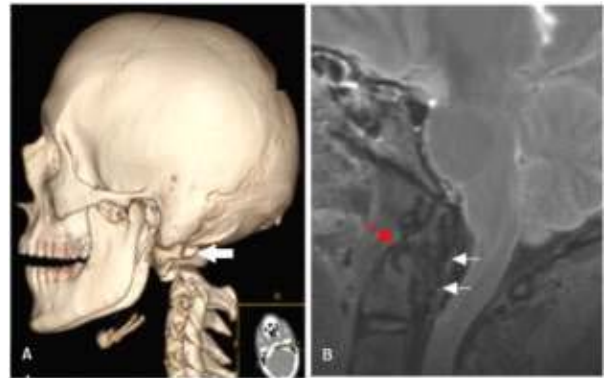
Deceased patient due to trauma caused by vehicular collision. (a) Computed tomography; (b) magnetic resonance imaging.
